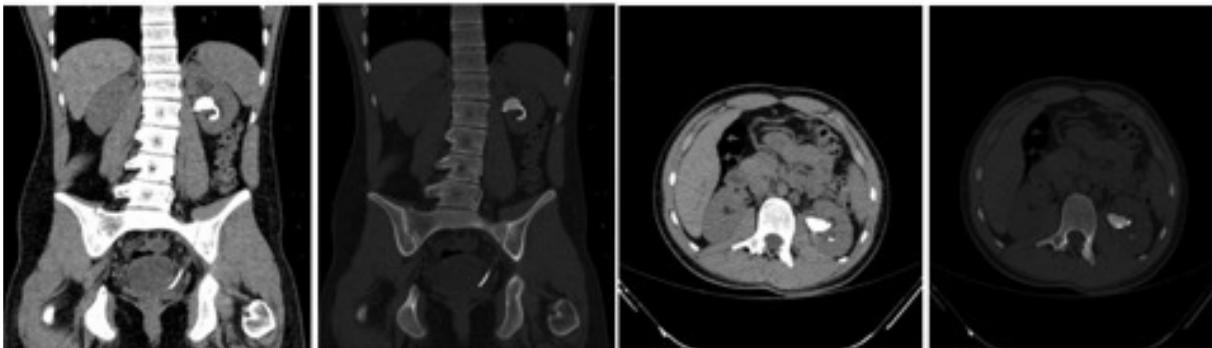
Control CT images after kidney stone recurrence
